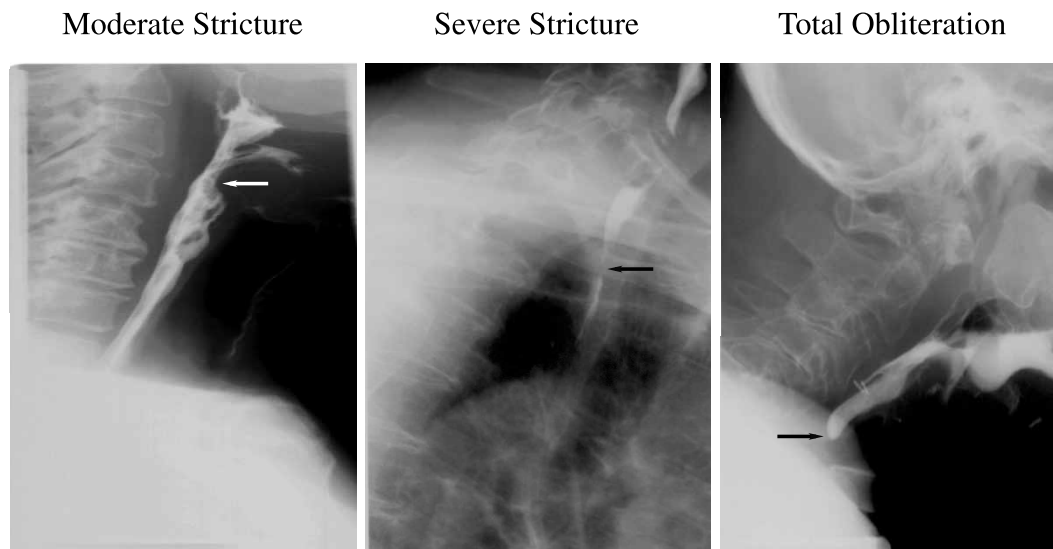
Radiographs showing three representative cases of patients with radiation-induced strictures. They follow the classification order of increasing severity: moderate stricture, severe stricture and total obliteration. The radiographs were produced using barium as the contrast media. The arrows in the graphs point out the parts of the esophagus where the strictures have been formed.
